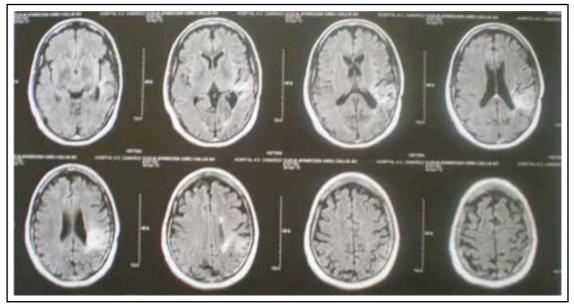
March 2004 MRI: Period of stereotactic biopsy. Temporo-parietal lesion left with adjacent edema and gliosis. There's midline shift.
